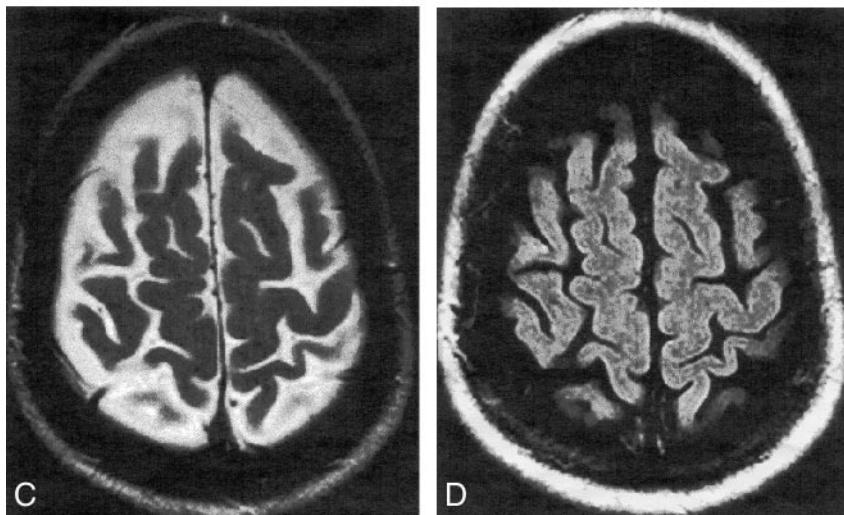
Axial MR images obtained in a 65-year-old man with aphasia that rapidly resolved within 3 hours of onset.
